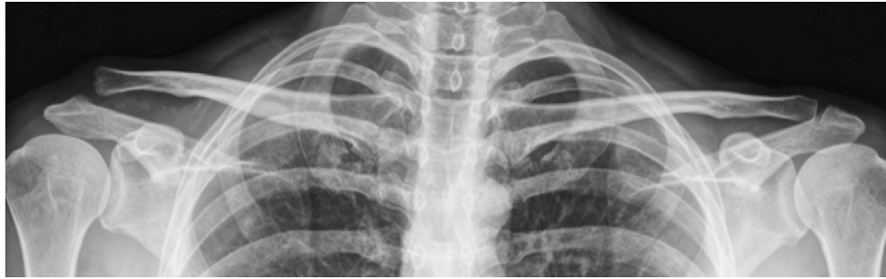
True anteroposterior standing radiograph of the acromioclavicular joint bilaterally, with the x-ray beam directed with a 10° to 15° cephalic tilt (the Zanca view) and with use of 50% of the exposure that is used in making a standard radiograph of a normal shoulder, comparing the injured right acromioclavicular joint (left side of image) with the normal left acromioclavicular joint (right side of image).
